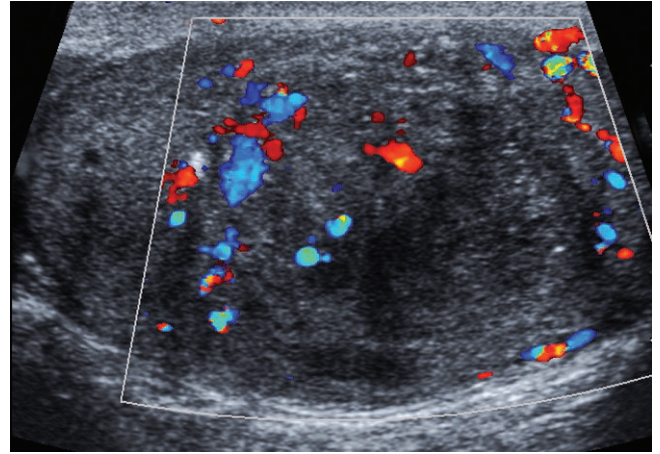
The longitudinal color Doppler sonographic image of the testis shows internal vascularity in the mass.
